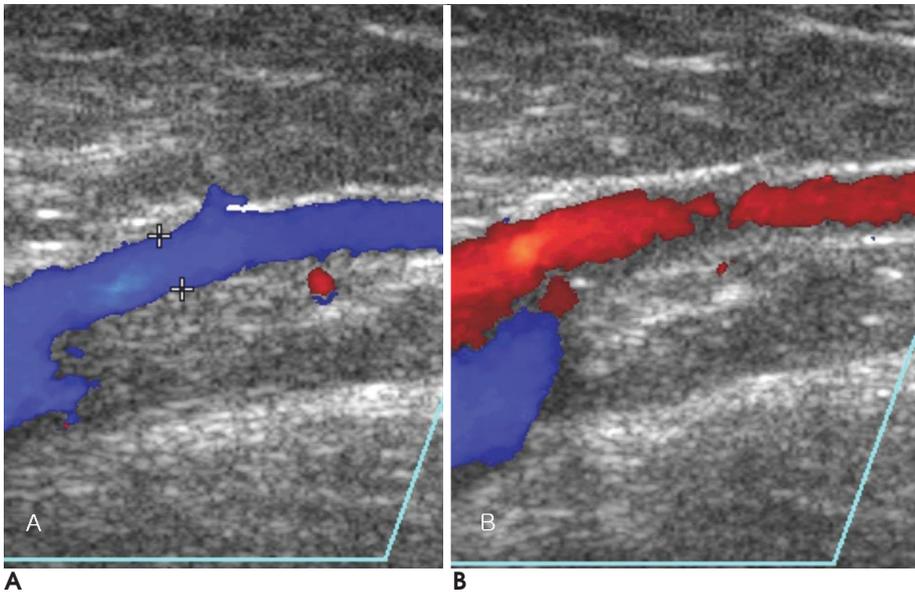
Grade II reflux : A. Color Doppler image of great saphenous vein in resting state. B. Color Doppler image with Valsalva maneuver show continuous reflux without dilatation in great saphenous vein.
